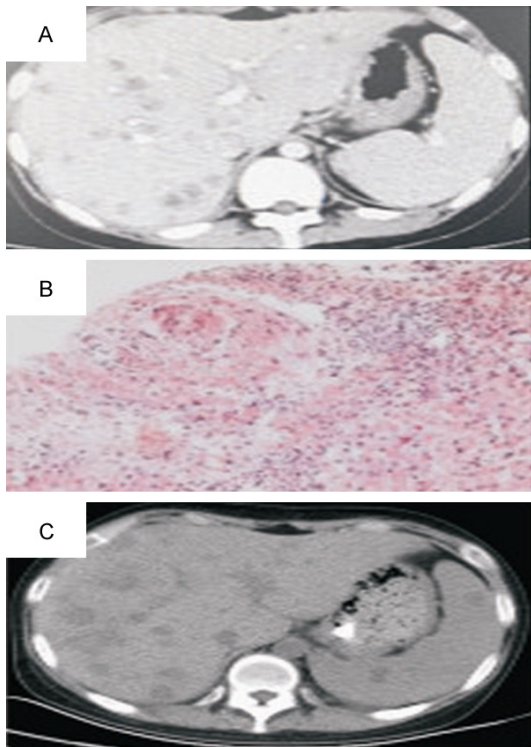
Presentation of Case 1. A. CT scan showed multiple nodular lesions in the liver with diameter of 4-10 mm, in enlargement spleen with diameter of about 9 mm. B. Liver needle biopsy showed that portal area was infiltrated by lymphocytes and monocytes and there was fibrocytes proliferation with hyaline change of collagenous fibrils. C. CT scan showed that liver nodular lesions became larger after anti-fungal treatment.
